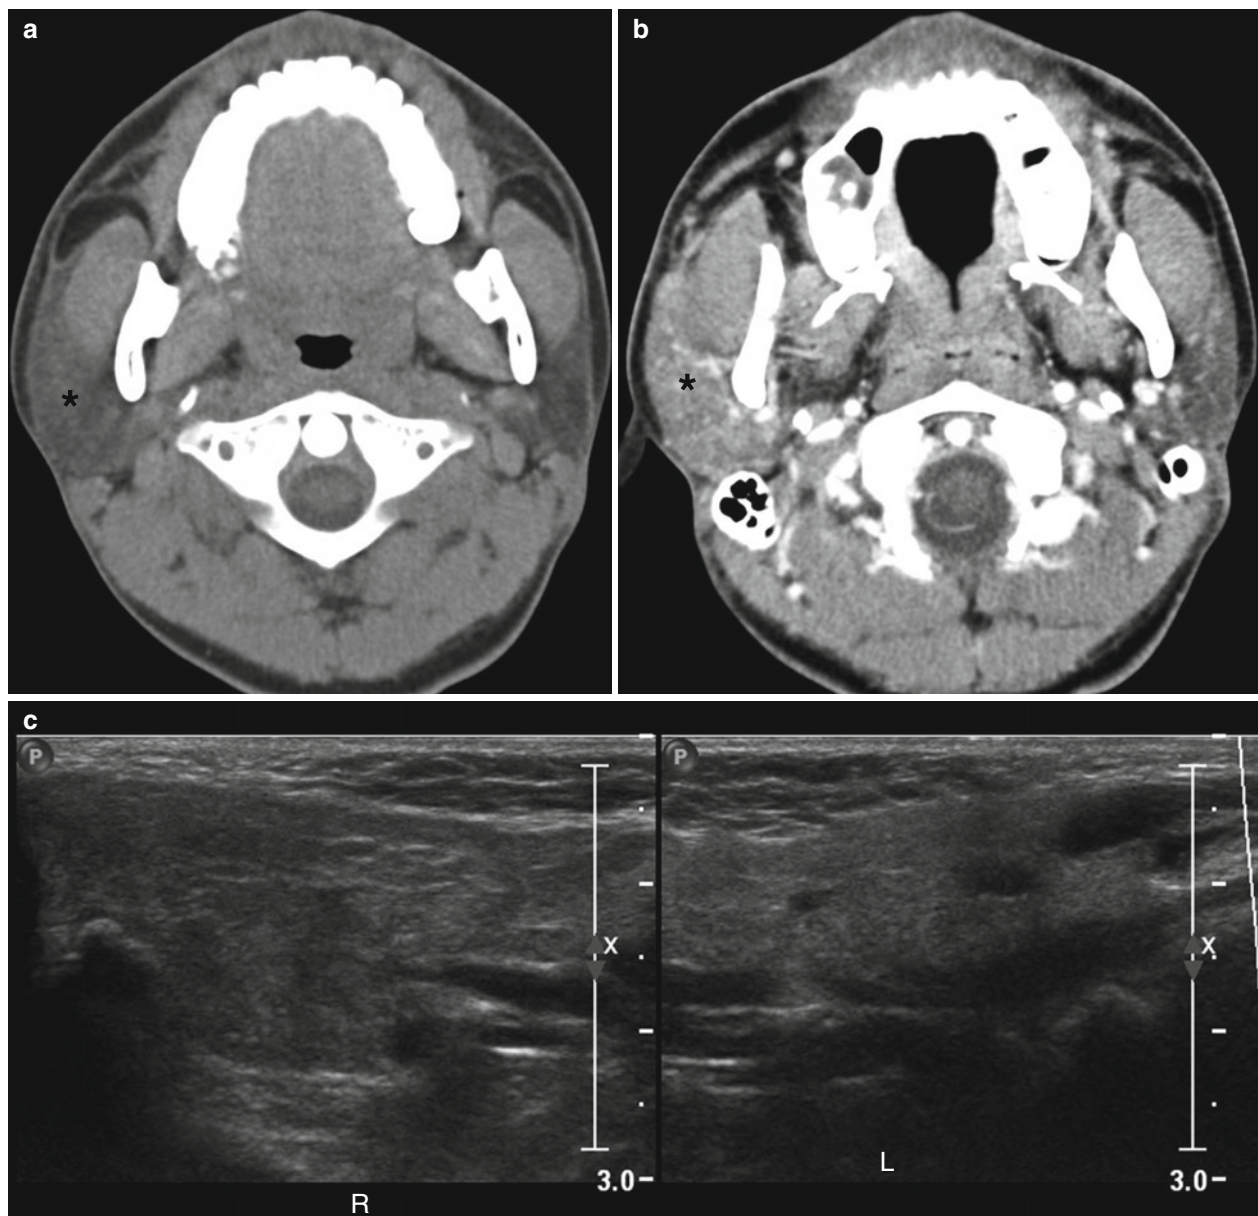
Acute parotitis. (a, b) Precontrast (a) and postcontrast (b) CT images through the parotid gland show diffuse enlargement of the right parotid gland with increased enhancement, in keeping with sialadenitis of the right parotid gland (* in a and b). (c) Compare the enlarged right (R) parotid gland to the left side (L) on neck ultrasound
